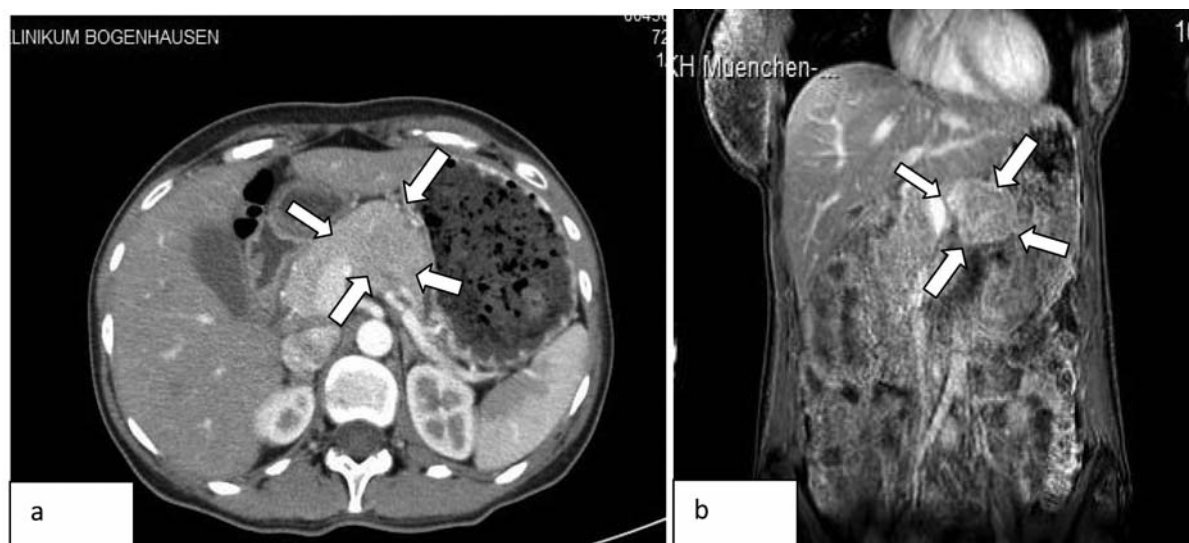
Radiological abdominal imaging demonstrating a large well-defined, heterogeneously enhancing mass involving the pancreatic tail (arrows) consistent with a neuroendocrine tumor. a: Computed Tomography; b: Magnetic Resonance Imaging.
